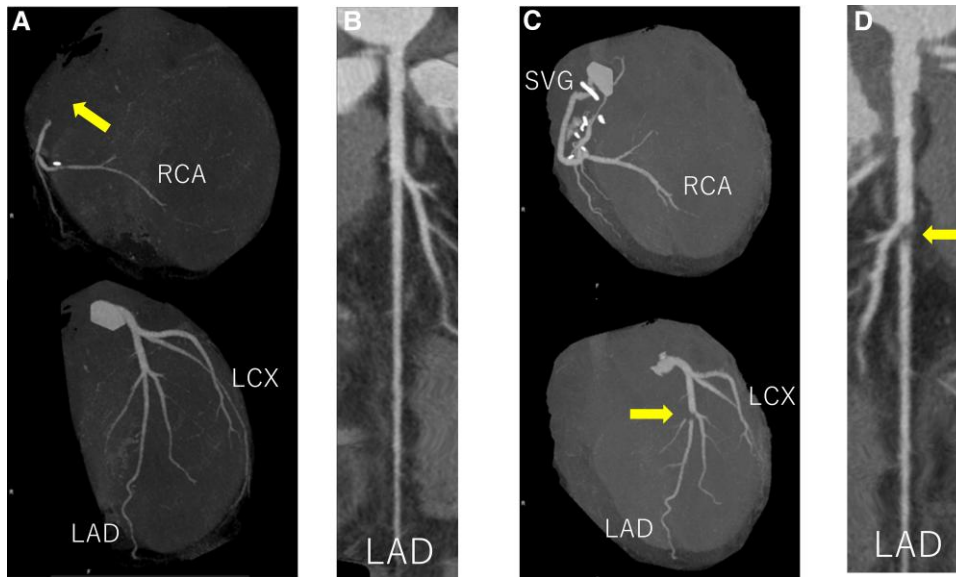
(A and B) Coronary computed tomography angiography (CCTA) before 2nd surgery showing no stenoses or atherosclerotic changes in LAD artery. Native RCA was occluded at ostium (arrow) but well-enhanced in the middle to distal portions. (C and D) CCTA after 2nd surgery showing severe stenosis of the mid-left anterior descending (LAD) artery (arrow). RCA, right coronary artery; LAD, left anterior descending; LCX, left circumflex; SVG, saphenous vein graft.
